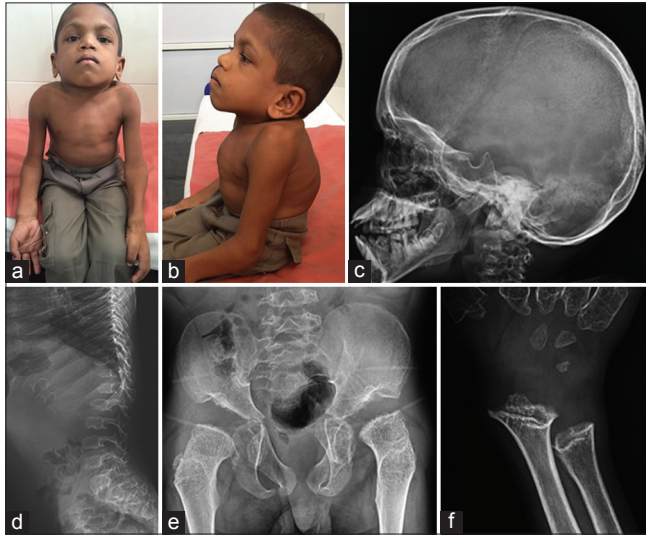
(a-f) A 9-year-old child diagnosed as mucopolysaccharidosis possibly Hurlers syndrome shows kyphoscoliosis, short trunk dwarfism, barrel-shaped thorax, large head. Radiographs of the same child, lateral view of dorsolumbar spine shows inferior end plate beaking and oar-shaped ribs, pelvis AP view shows abnormal configuration of pelvis with overconstriction of iliac blades and wide flaring of iliac wings with dysplastic changes in proximal femoral epiphyses, lateral skull radiograph showing elongated J-shaped sella, and wrist radiograph shows proximal pointing metacarpals and angulated radius and ulna
